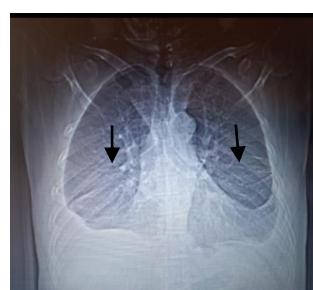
Chest x-ray PA view shows bilateral pleural effusions.
